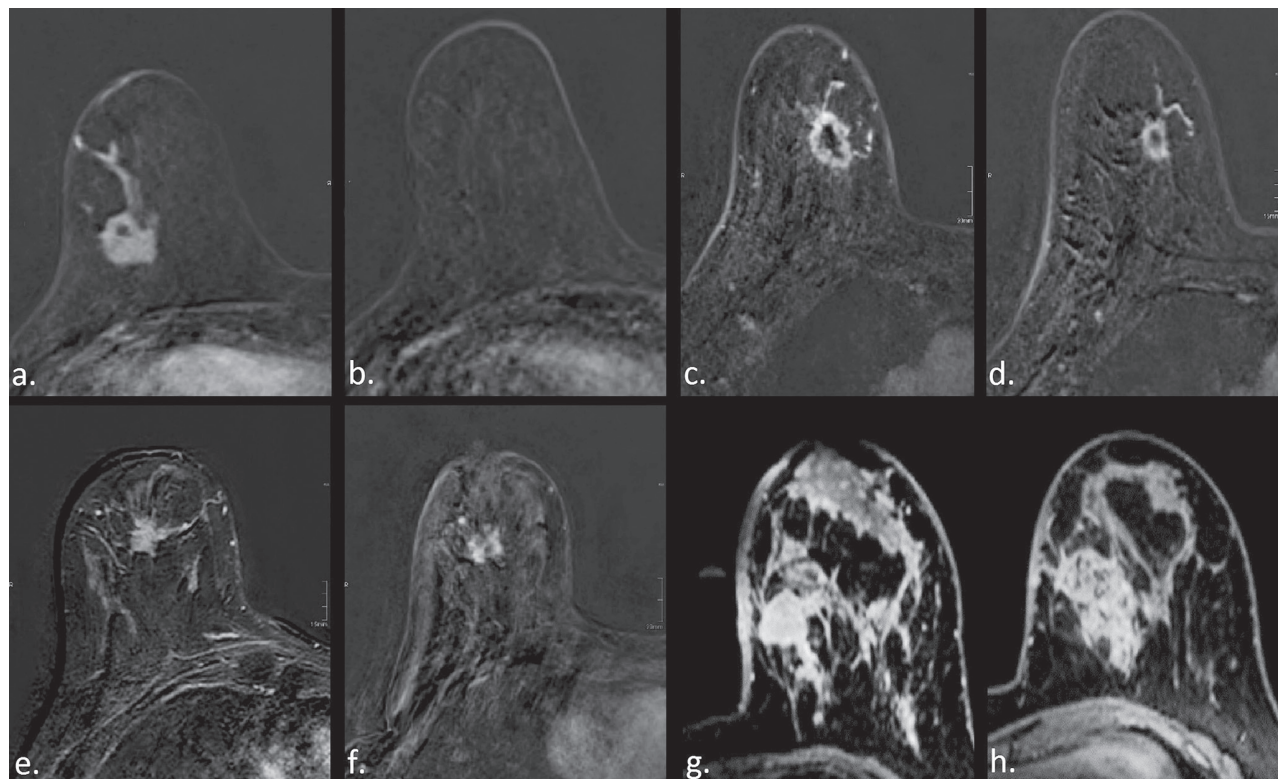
RECIST response categories in MRI. a.-b.: Complete response. G2 IDC with associated DCIS; a. baseline, b. after 6 NAC cycles. c.-d.: Partial Response. G2 IDC; c. baseline, d. after 6 NAC cycles. e.-f.: Stable Disease. G2 ILC; e. baseline, f. after 6 NAC cycles. g.-h.: Progressive Disease. G3 IDC; g. baseline, h. after 4 NAC cycles. G: grade
